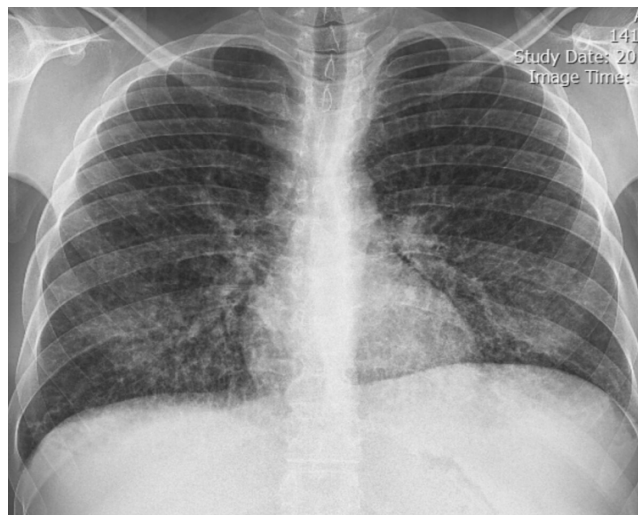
Chest-x-ray diffuse reticulonodular opacities in both lungs are visible
